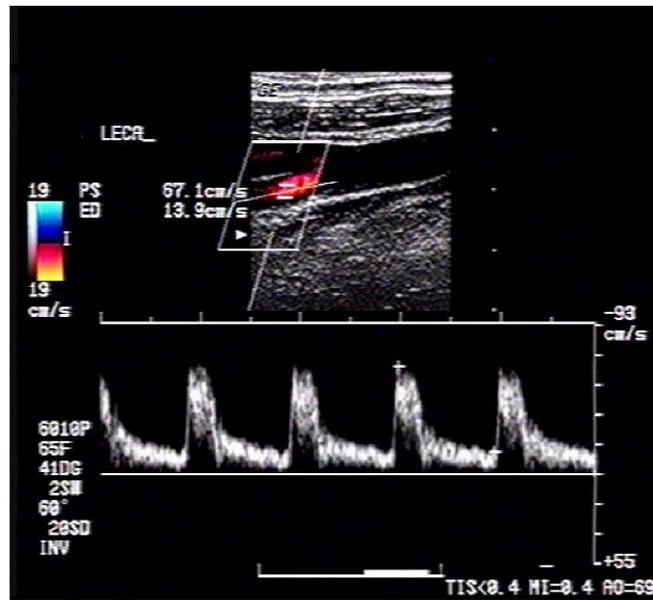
Color and Pulse-wave Doppler of Proximal ECA
